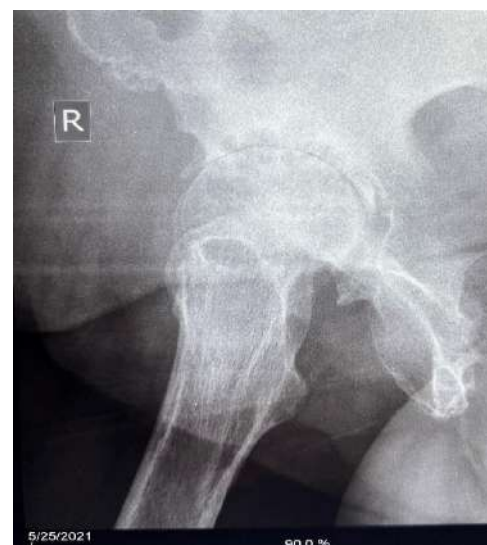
X-ray of the right hip joint 6months post procedure (May 2021)- As shown in Fig. 2a.
